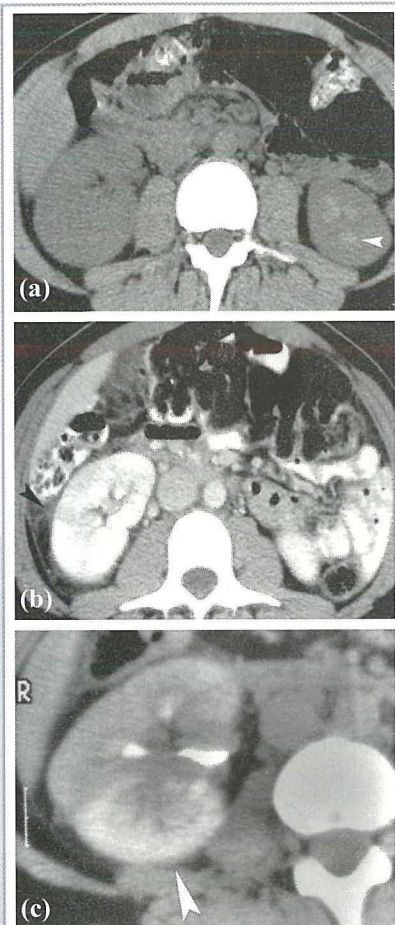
(a) Unenhanced CT scan showing enlargement of the infected right kidney and loss of medullary pyramids (note pyramids on normal left kidney (arrowhead)). (b) Early enhanced CT scan showing area of diminished perfusion (arrow). (c) Delayed scan (note contrast material is already in the renal calyces) showing an area of persistent contrast enhancement (arrowhead).
